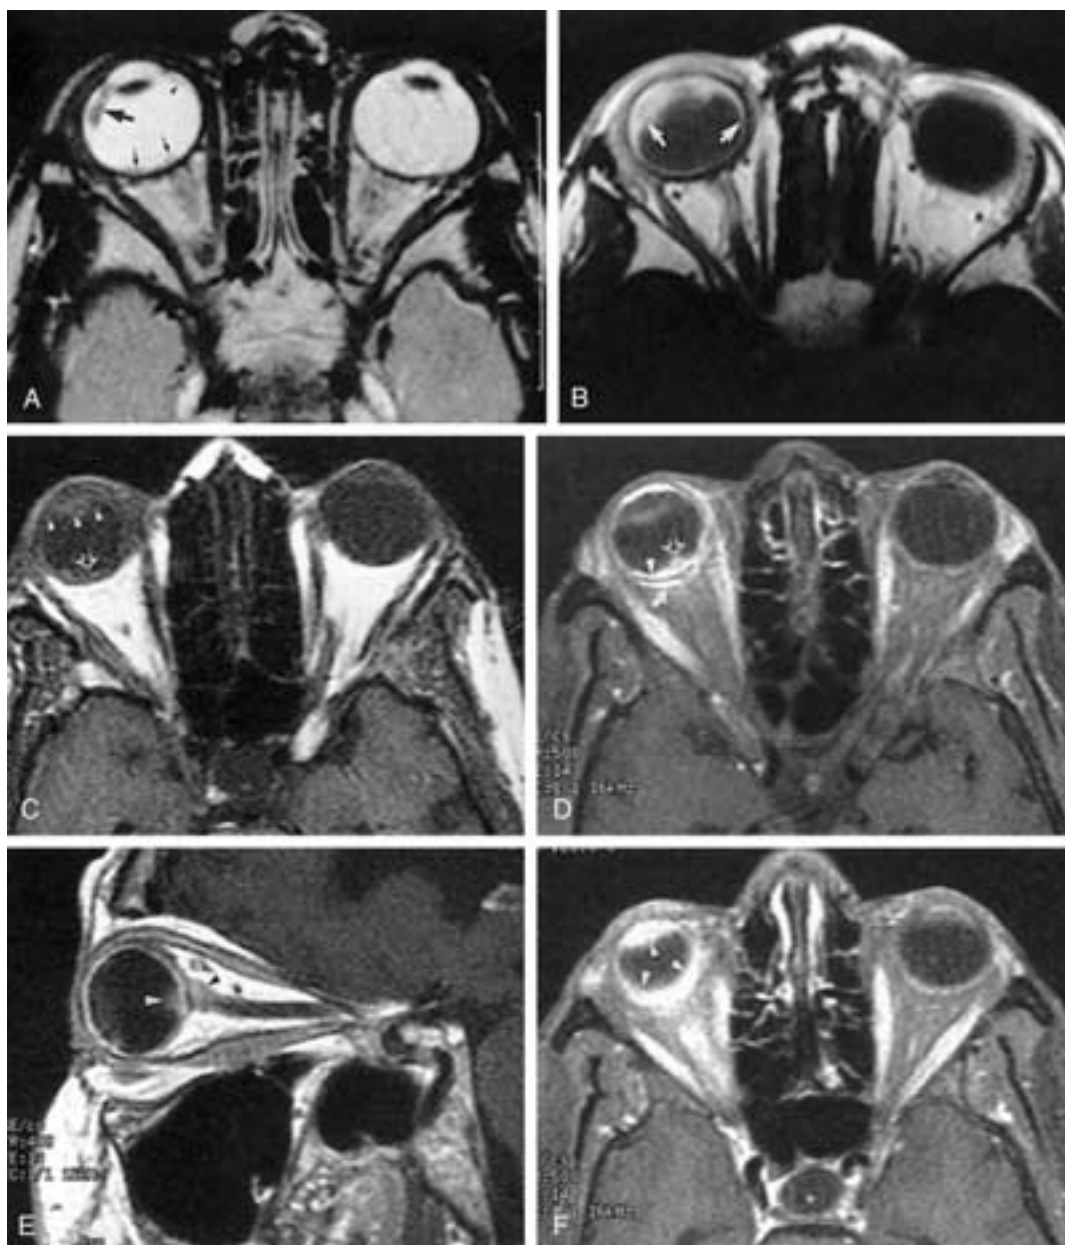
(1) Granulomatous uveitis. A, Axial T2-weighted (2800/95, TR/TE) MR image shows hypointense lesions (*arrows*). B, Axial enhanced, T1-weighted (400/15, TR/TE) MR image shows marked enhancement of the entire uveal tract (*arrow*). Rb is unlikely because the lesion appears to have arisen within the uvea rather than the retina. (2) Ocular sarcoidosis panuveitis. C, Unenhanced axial T2-weighted (500/13, TR/TE) MR image shows nodular thickening of the posterior aspect of the right globe (*arrow*) and thickening of the anterior segment (*arrowheads*) of the right globe. D, Enhanced axial fat-suppressed, T1-weighted (500/13, TR/TE) MR image shows nodular enhancement of the posterior aspect of the right globe (*arrowhead* and *open arrow*) related to granulomatous involvement of the choroids. Note the enhancement of the anterior segment of the right globe and the abnormal enhancement of Tenon's capsule (*curved arrow*). E, Enhanced sagittal T1-weighted (400/13, TR/TE) MR image shows granuloma at the optic disc (*white arrowhead*) as well as involvement of the optic nerve (*black arrowhead*). F, Enhanced axial fat-suppressed, T1-weighted (500/14, TR/TE) MR image shows enhancement of the markedly thickened uveal tract (*arrowheads*).
